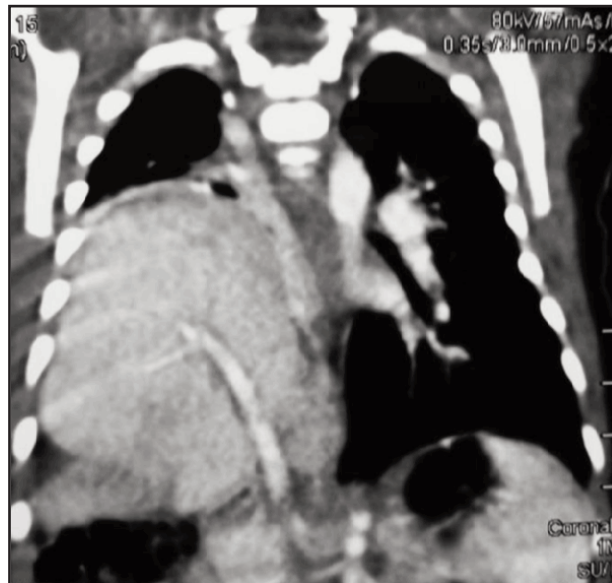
Contrast enhanced computed tomography of the thorax (CECT thorax) showed presence of liver parenchyma in the right thoracic cavity predominantly at the posterior aspect with intact anterior and posterior hemidiaphragm.
